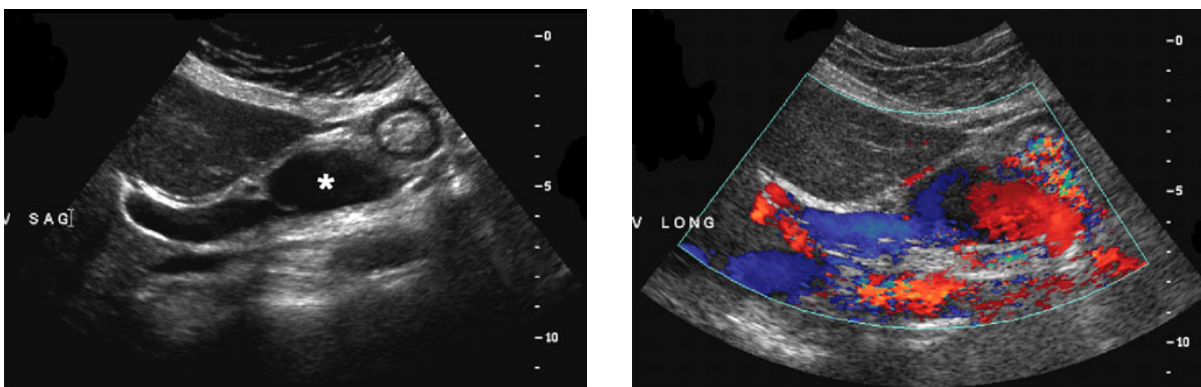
61-year-old woman with extrahepatic portal vein aneurysm. Gray scale (A) and color Doppler (B) ultrasound images delineate extrahepatic location and patency of portal vein aneurysm (asterisk).
